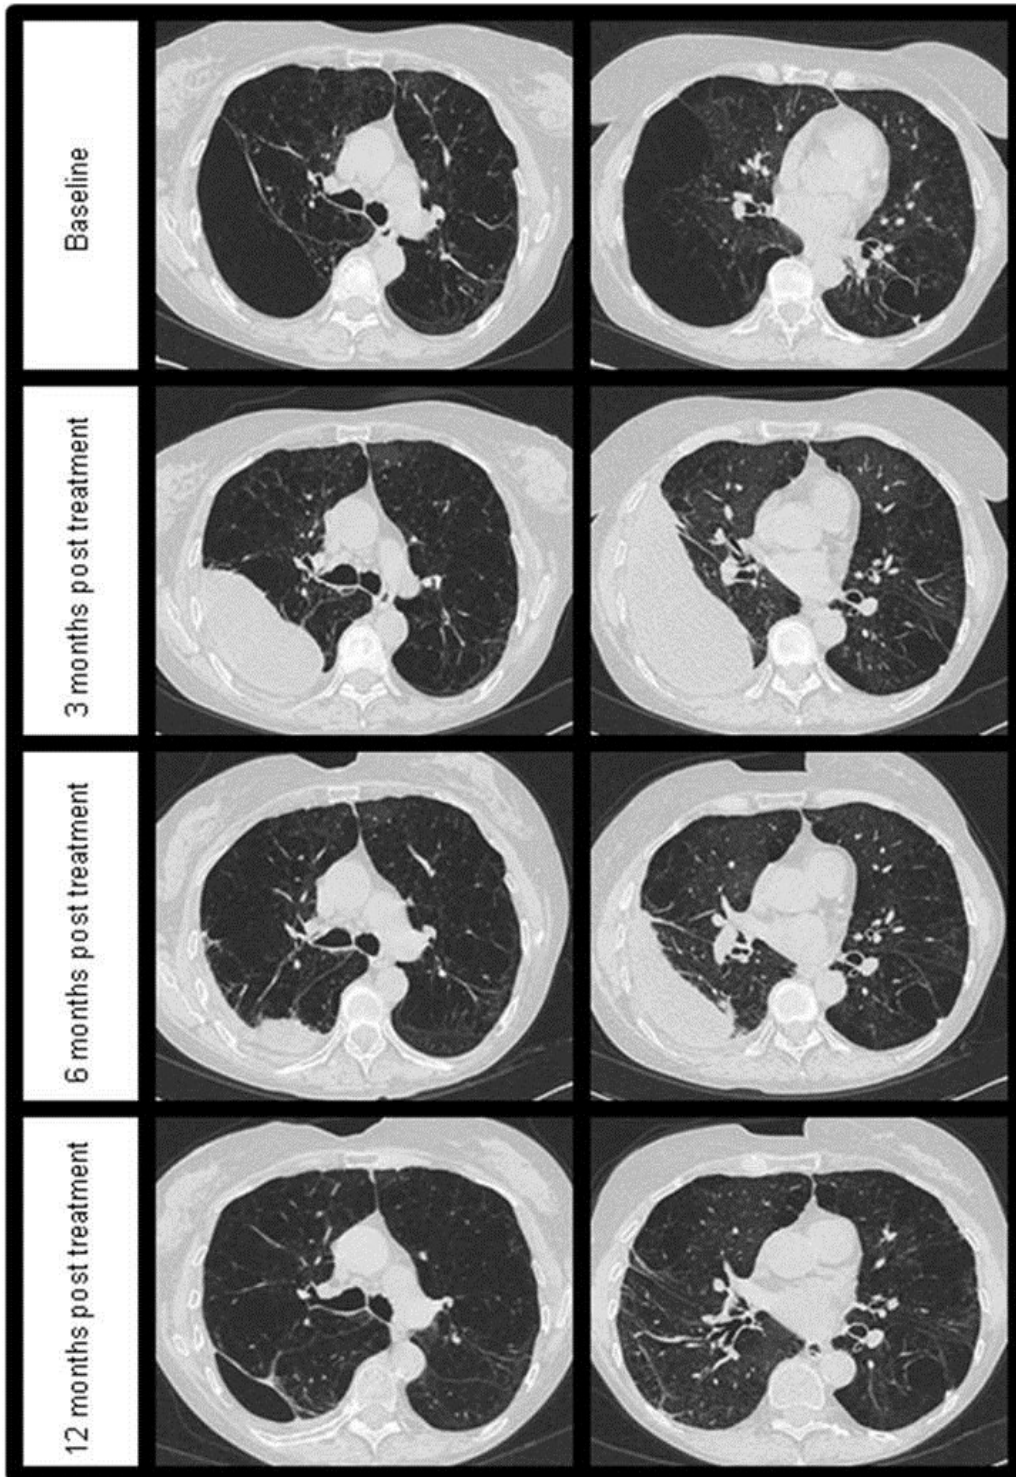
Axial CT scan images of Subject 1 at the levels of the T4 (carina) and T6 vertebrae at baseline, 3, 6 and 12 months following BIABI treatment. There is progressive and dramatic shrinking in the size of the bulla.
